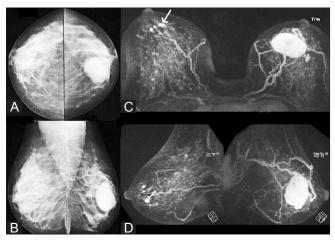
(A-D): A 48-year-old female presented with proven malignancy in the left breast. X-ray mammography CC (A) and MLO (B) views show a heterogeneously dense breast and a large mass in the left breast (proven malignancy). Axial (C) and sagittal oblique (D) 1-minute subtraction MIP images show an enhancing mass in the left breast (proven malignancy) and subcentimeter-enhancing lesion in the retroareolar region of the right breast (arrow). The right breast lesion was surgically excised after MRI-guided wire localization. HPE revealed DCIS. This was a true-positive MRI finding
